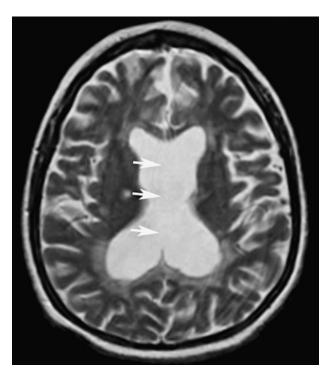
MRI T2-weighted axial image revealing absence of the septum pellucidum (arrows) and enlargement of the lateral ventricles which appear dysmorphic and fused.
